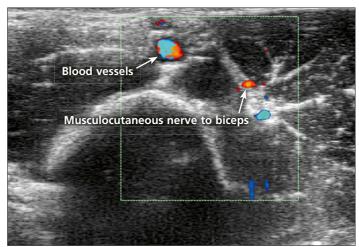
Color Doppler images show the appearance of the vessels wrapped with nerve.
